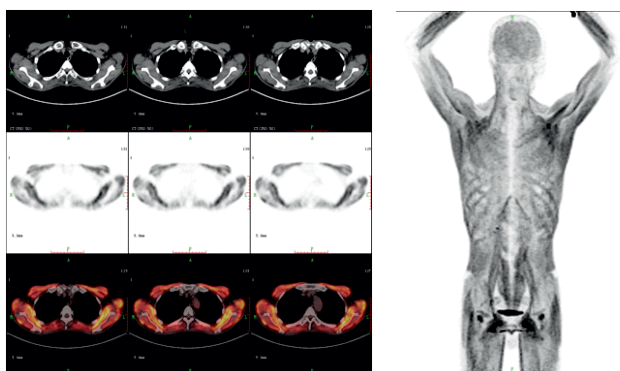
^{18}F -FDG PET coronal (A) and MIP (B) images showed a diffuse and symmetric, homogeneous increased ^{18}F -FDG uptake in all muscles. The liver was not well visualized with decreased brain FDG uptake.
